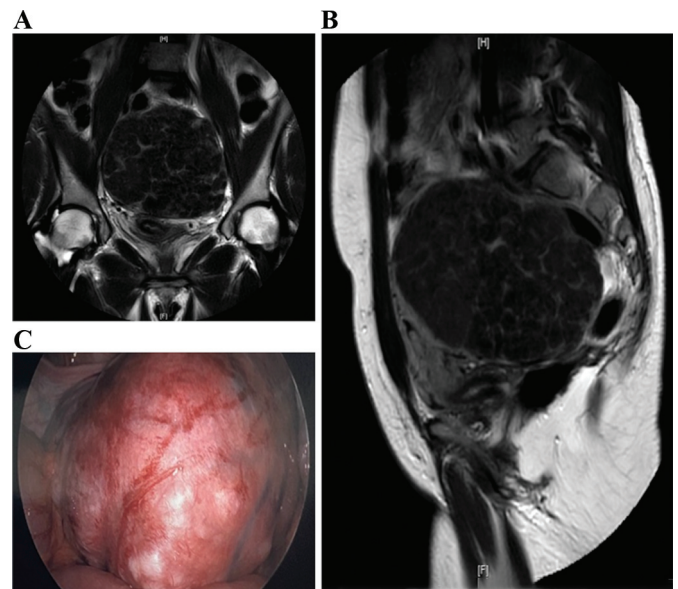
A) Magnetic resonance image showing large fibroid measuring 12.5 centimeters by 13 centimeters by 12.5 centimeters and extending to the pelvic side wall bilaterally where it is impinging on the psoas muscles and obturator nerves laterally, coronal view. B) Magnetic resonance image showing large fibroid measuring 12.5 centimeters by 13 centimeters by 12.5 centimeters and compressing the bladder anteriorly and rectum posteriorly, sagittal view. C) Intra-operative image of dominant subserosal posterior fibroid arising from the posterior surface of the uterus occupying the entire posterior cul-de-sac up to the level of the sacral promontory.
